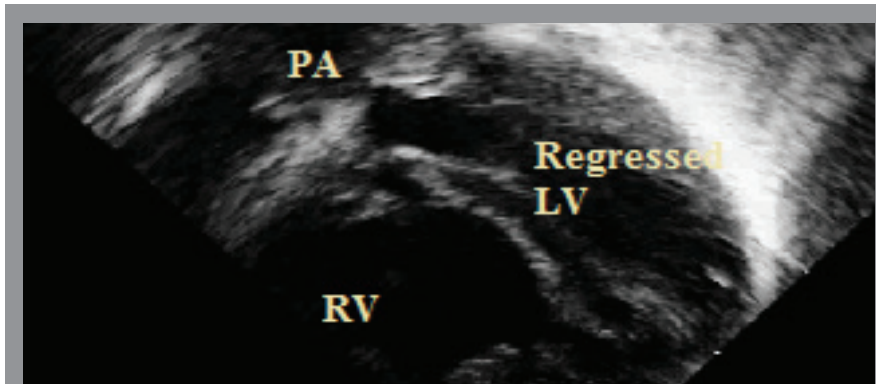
Echocardiography showing 4 chambered view on 5th day of life: Right ventricular(RV) dominance due to its connection to aorta (Systemic right ventricle). Interventricular shifts towards left ventricle due to low pressure LV (Sub-pulmonary ventricle) giving it a shape of banana. Still posterior wall thickness is preserved.
